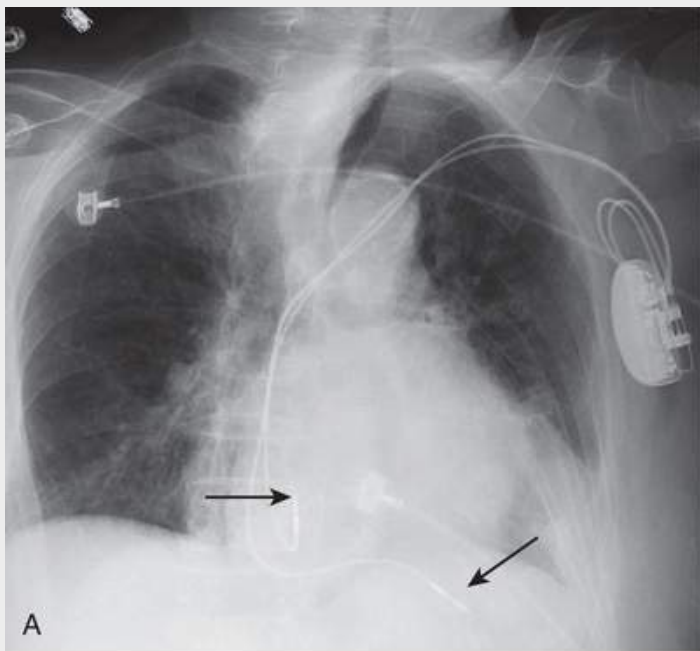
Transvenous versus leadless pacemakers. A, Radiograph of transvenous pacemaker with generator in left pectoral pocket. *Left arrow* denotes tip of atrial lead. *Right arrow* denotes tip of ventricular leads. Leads have active fixation screws. B, Radiograph of leadless capsule pacemaker implanted in right ventricular apical septum (*arrow*). C, Left panel, Transvenous pacemaker and lead to scale with one model of leadless capsule pacemaker. The lead's active fixation mechanism is shown in Fig. 41.1. Middle panel, Enlarged image of leadless capsule pacemaker. Right panel, Right anterior oblique cinefluoroscopy frame shows components of leadless capsule pacemaker.
